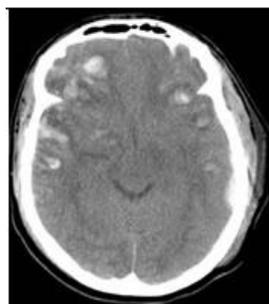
CT brain axial cut showing brain edema
